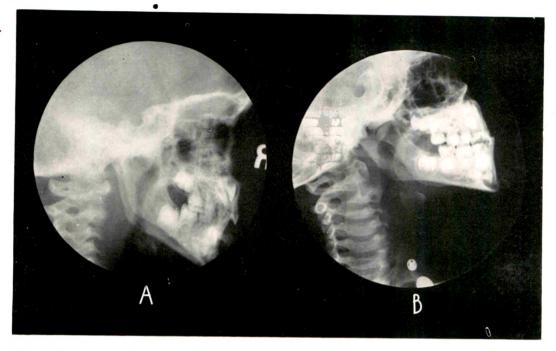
Case II. A, moderate retropharyngeal adenitis, associated with cervical adenitis and sinusitis. B, one month after roentgen therapy the retropharyngeal space is normal.
